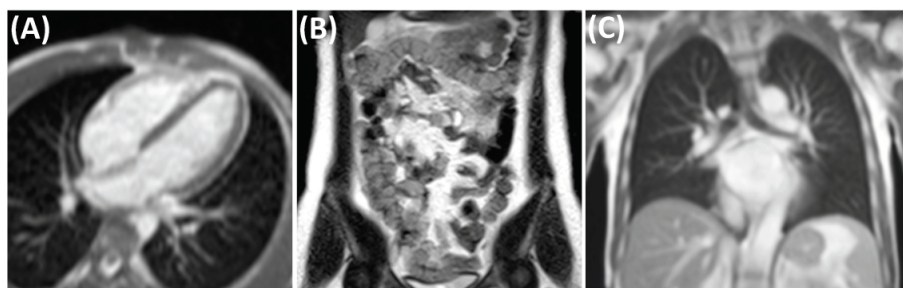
Demonstration of real-time bSSFP imaging using a high-performance low field (HPLF) MRI system (prototype 0.55T Aera, Siemens Healthcare, Erlangen, Germany). (A) Real-time bSSFP for MRI-guided invasive cardiovascular procedures (TE/TR = 2.0/4.0 ms, flip angle = 45°, in-plane resolution = 2mm, slice thickness = 8mm, GRAPPA rate 2, 250 ms temporal resolution, 4 fps). (B) Real-time bSSFP for dynamic intestinal imaging (TE/TR = 1.6/3.2ms, flip angle = 90°, in-plane resolution = 1.2mm, slice thickness = 10mm, GRAPPA rate 3, 1.2s temporal resolution for 6 slices, 0.8 fps). No bSSFP banding around the intestines is observed using the HPLF system configuration. (C) Real-time bSSFP for dynamic respiratory imaging (TE/TR = 1.21/2.4ms, flip angle = 70°, in-plane resolution = 1.8mm, slice-thickness = 15mm, GRAPPA rate 2, 250 ms temporal resolution, 4 fps). Due to the reduced susceptibility, higher quality imaging of lung parenchyma is feasible.
